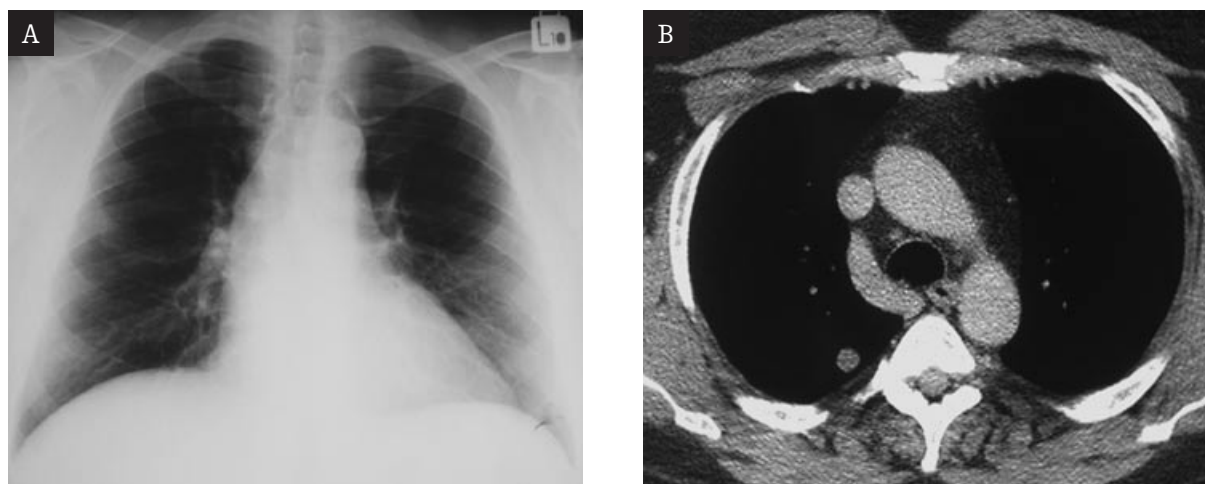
Comparison of the X-ray and CT images of the pulmonary hamartoma – difficulty of identification of the lesion on chest X-ray is visible.
